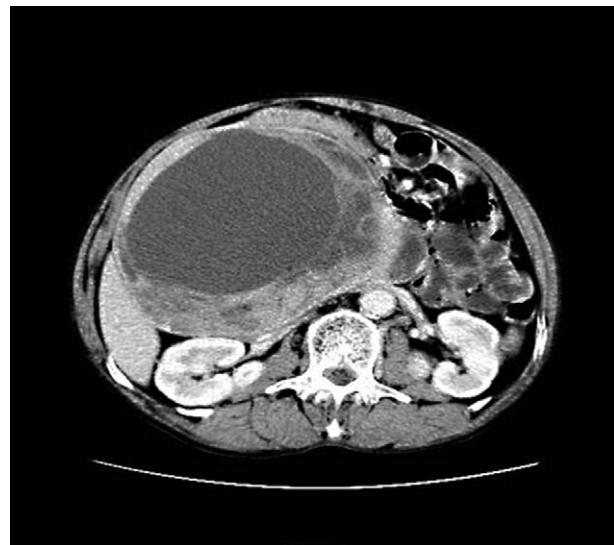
Contrast-enhanced computed tomography of the abdomen (axial view), showing a giant cystic solid neoplasm extending from the right upper quadrant of the retroperitoneum to the pelvis.
